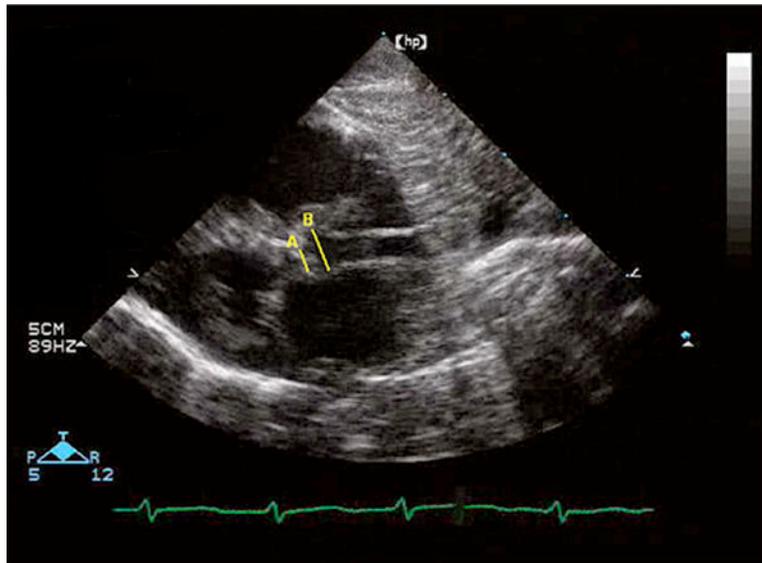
Aortic annulus and aortic root measurements. This parasternal long-axis view shows measurements of the aortic annulus (*A*) and aortic root (*B*)
